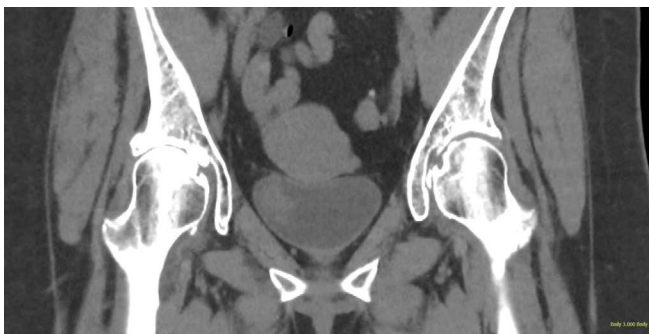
CT image showing lesion along right side of the bladder.
